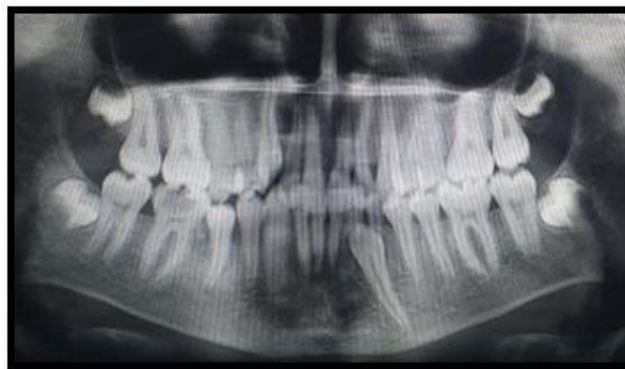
Orthopantomogram shows interstitial alveolar bone loss and subgingival calculus wrt 45,46.
